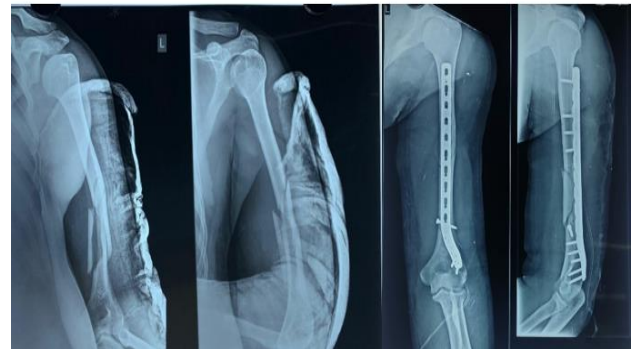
(Case 2) Pre-op and post-op radiographs.
